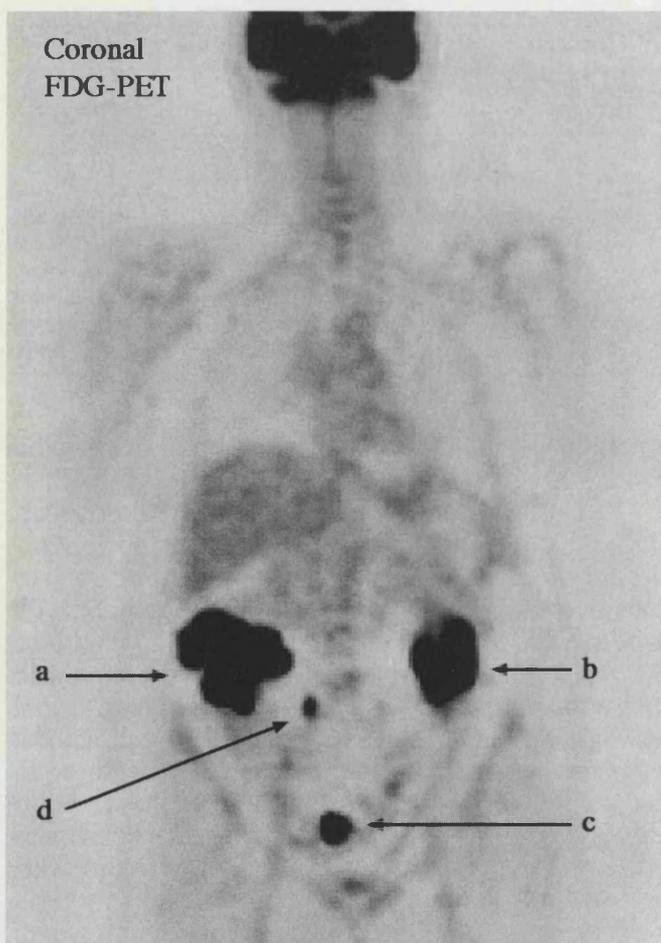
Coronal FDG-PET scan demonstrating a large primary adenocarcinoma of the ascending colon (a) overlying the right kidney. Also visualised are large jejunal (b), terminal ileal (c) and peritoneal lymph node (d) metastases. All lesions were confirmed at surgery.
